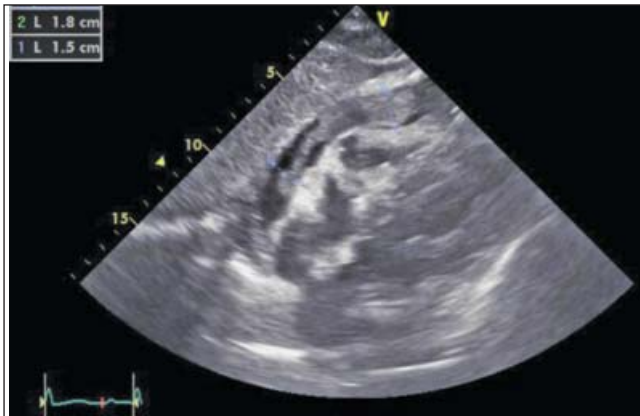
Echocardiogram showing pericardial effusion with co-agulum.
